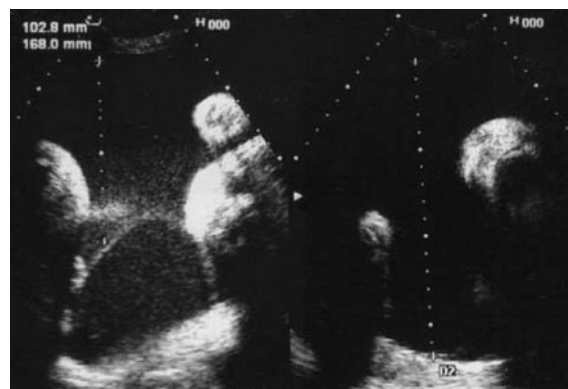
Ultrasonographic findings: The MVP of twin B is 10.2 cm.
